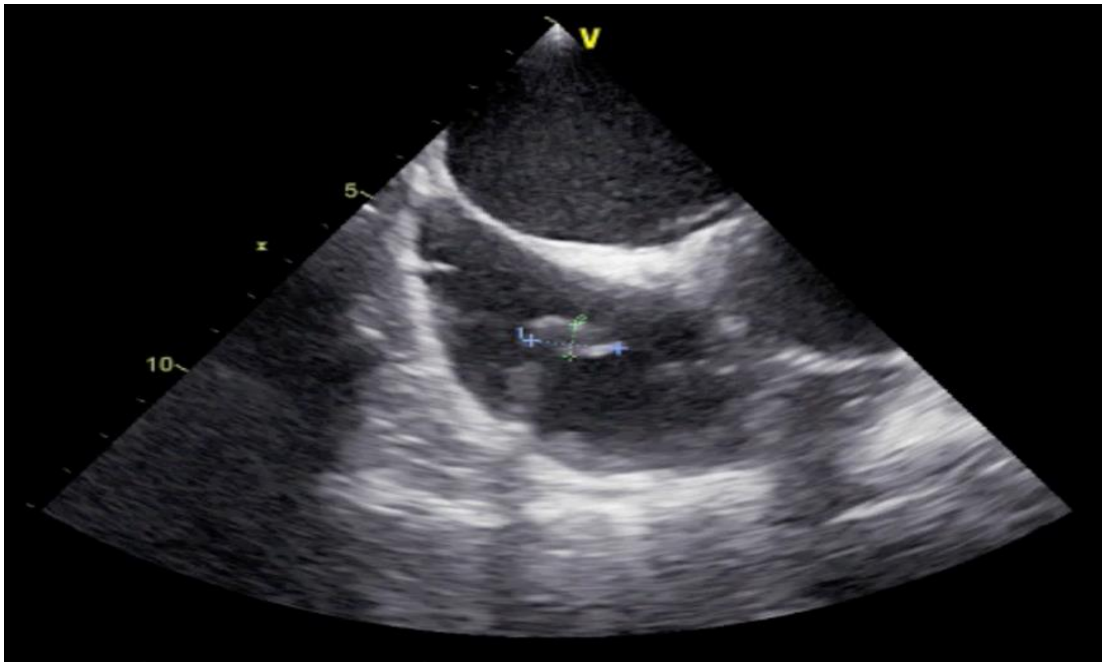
A mobile mass around the lead was observed during a transesophageal echocardiography study.
